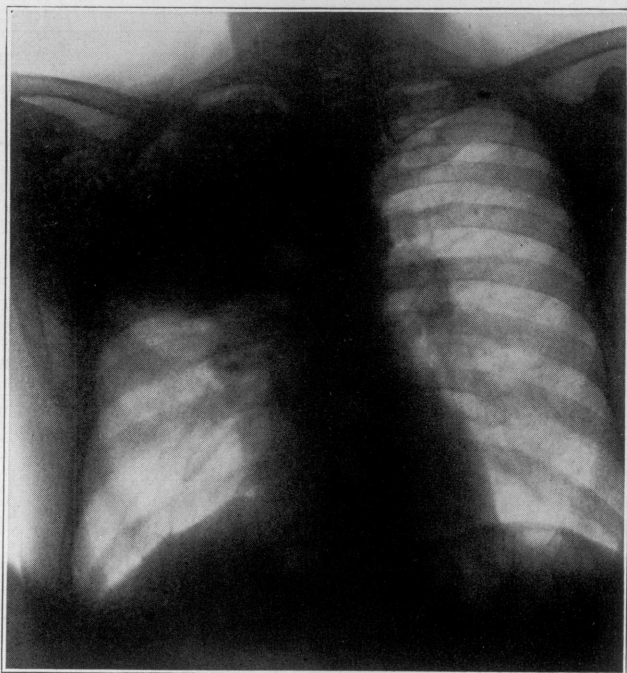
Pneumothorax decreased; roentgenographic diagnosis: tumor or sacculated fluid rather than chronic pneumonia.
